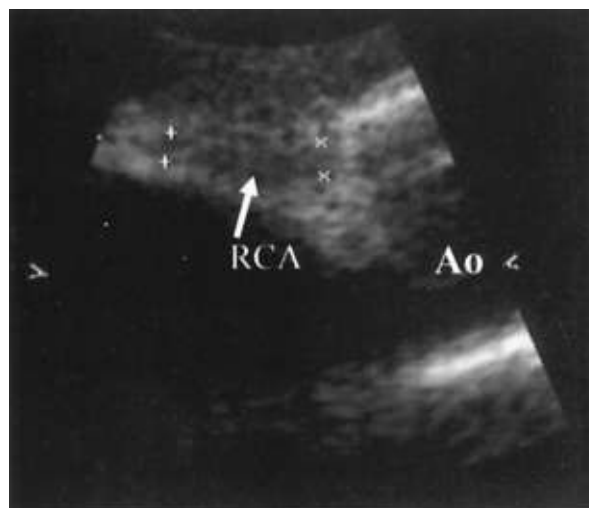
Right coronary artery on echocardiography. The orifice of the right coronary artery could not be identified.
